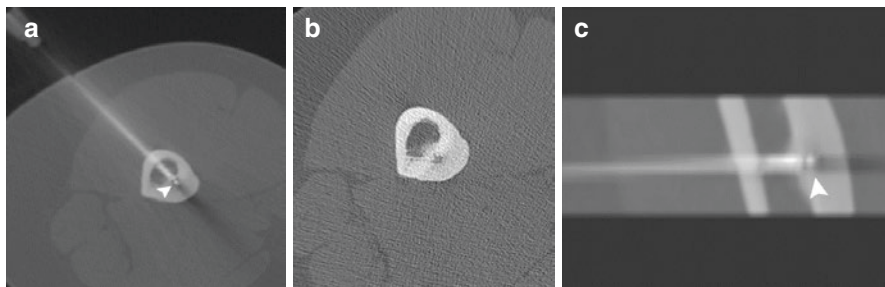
(a) CT-guided bone biopsy of a small lytic lesion involving the medial cortex of the right femur diaphysis with thick cortical bone surrounding the lesion. (b) Penetration by drilling using a lateral approach with an orthogonal, safer, approach to the bone surface (*arrowhead*). (c) Multiplanar reformatted images may allow better visualization of the needle pathway in small lesions (*arrowhead*). Final diagnosis was osteoid osteoma. A thermal ablation was performed immediately after the bone biopsy
